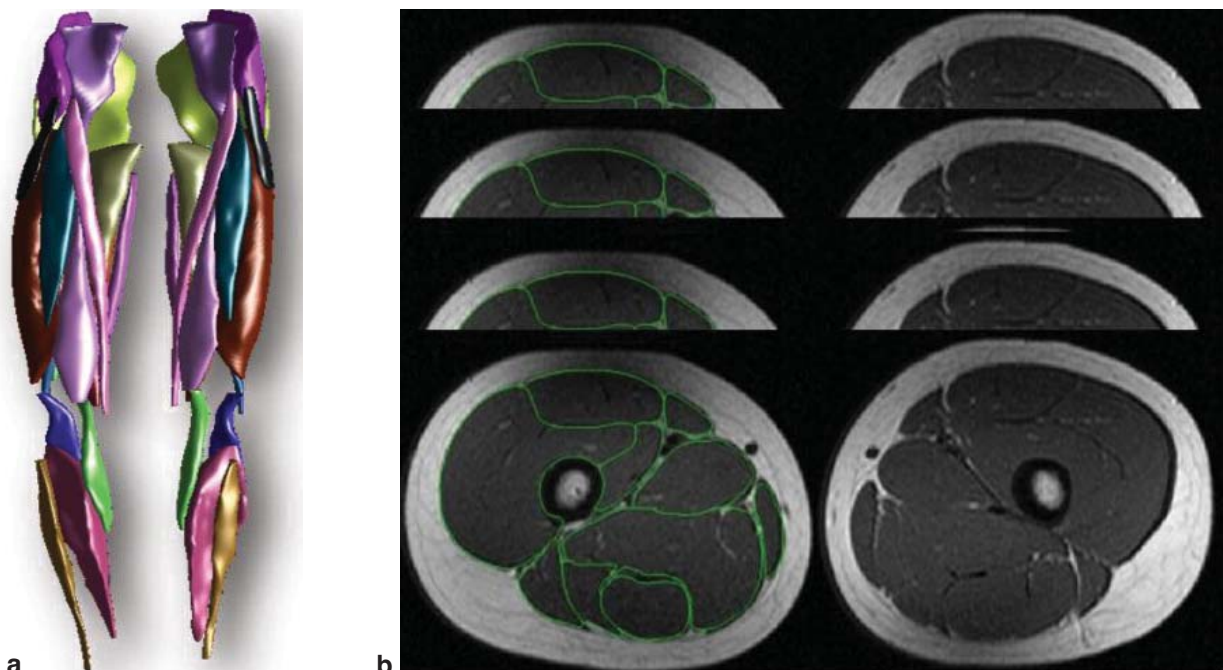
Three-dimensional lower limb muscle reconstructions: a) From axial slices b) Using magnetic resonance imaging
